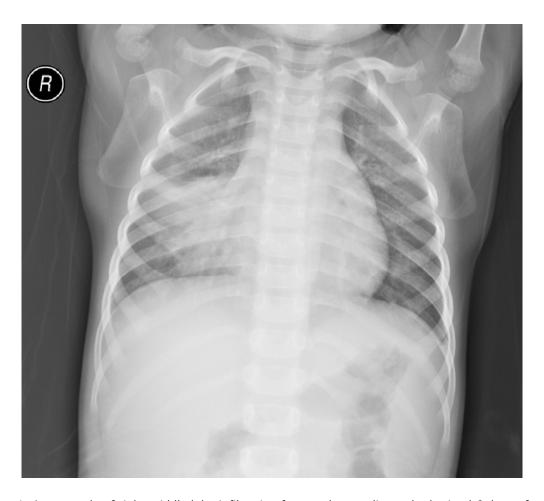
An example of right middle lobe infiltration from a chest radiograph obtained 6 days after the onset of symptoms in a 5-month-old girl with influenza B_{\circ} 76x69mm (300 x 300 DPI)
